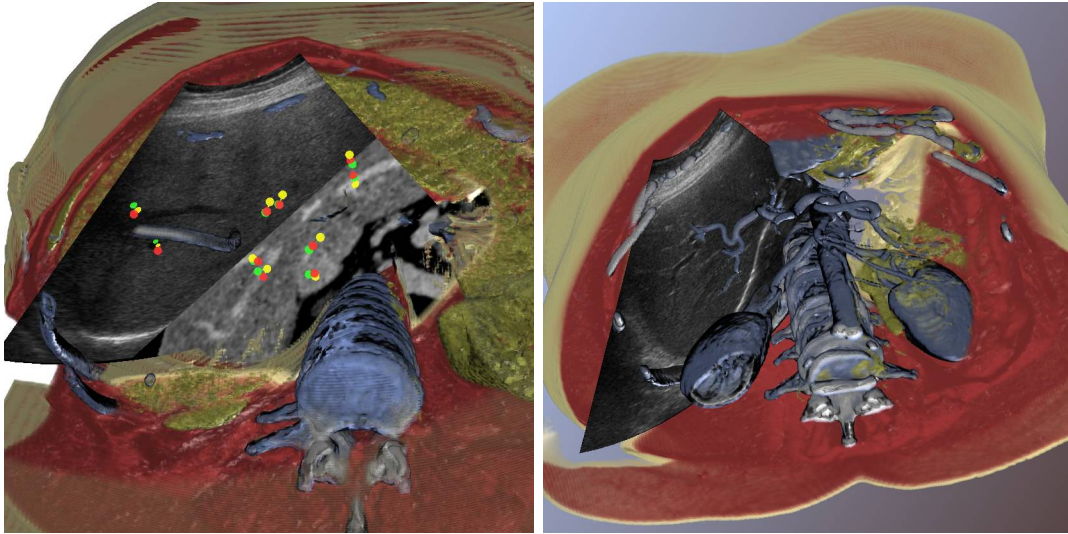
Left: Registered liver of patient 9 with fiducial points (yellow=CT, green=initial US, red=registered US), an oblique CT plane and contextual cutaway volume rendering of CT. Right: Another example of the importance-driven visualization, transversal ultrasound image of the liver with early-arterial phase CTA.
